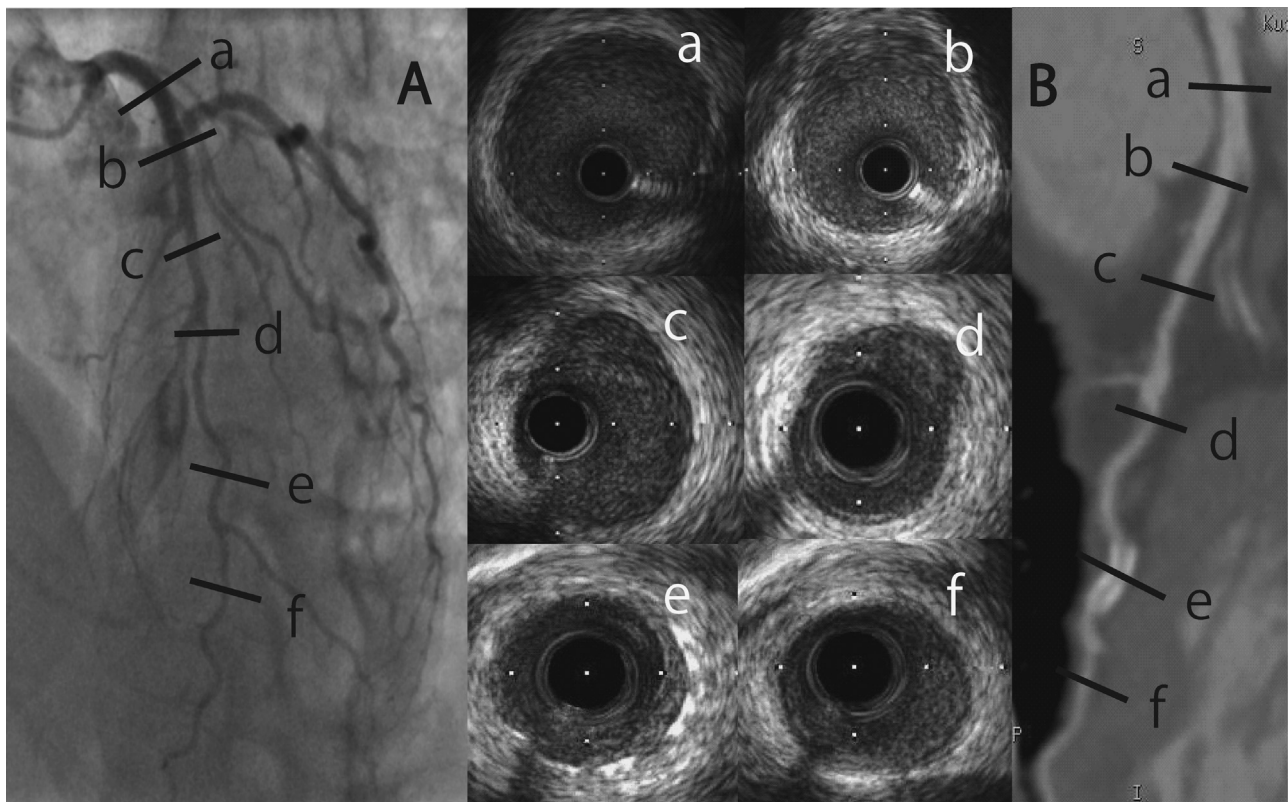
(A) Coronary angiography did not show any evidence of the coronary dissection. (B) Cardiac computed tomographic (CT) scan of the left anterior descending artery (LAD) performed 6 months after the initial event. (a–f) Intravascular ultrasonography showing the residual dissection from the ostium of the LAD to the proximal edge of the stent in accordance with the previous dissection: a, left main coronary artery; b, the ostium of the LAD; c, the proximal LAD; d, the mid LAD; e, in stent; and f, the distal lesion of the stent.
